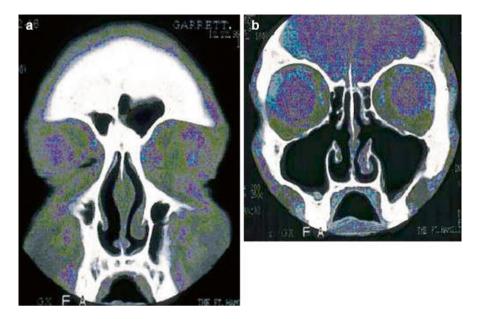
The CT scan of the patient in Fig. 12.6, demonstrating postsurgical changes but no evidence of active sinus disease
